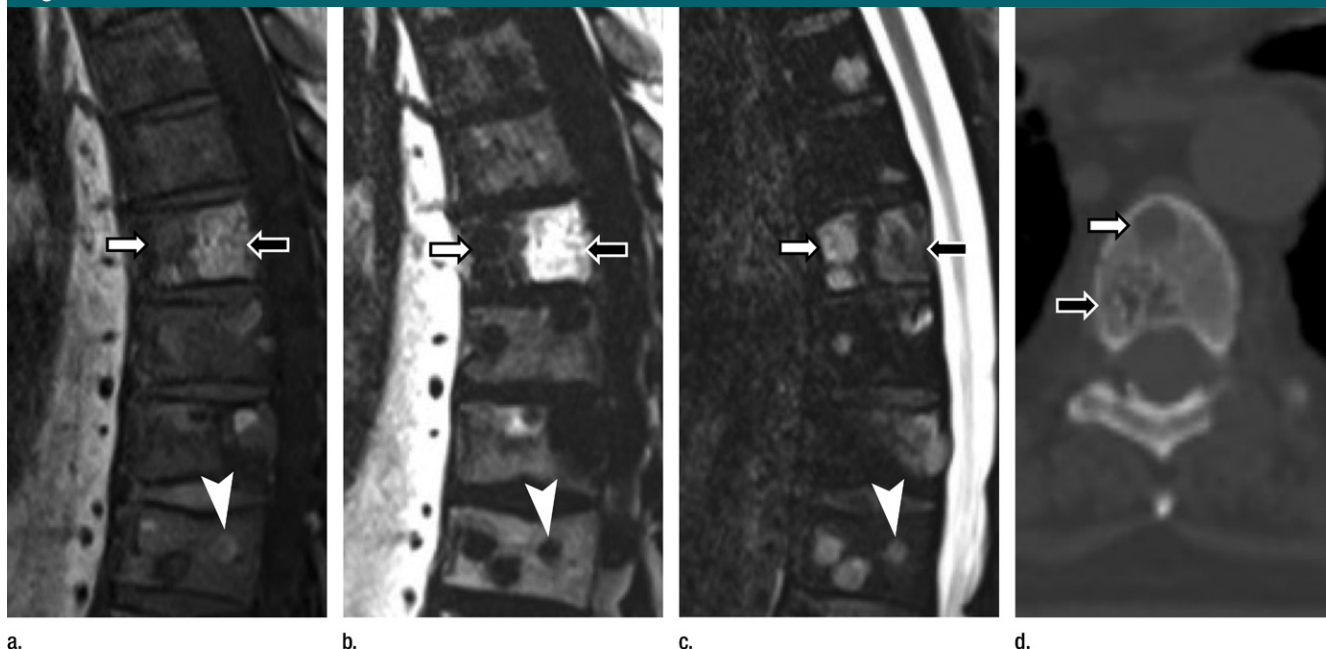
Images in a 66-year-old man with malignant melanoma and lytic bone metastases. Sagittal thoracic spine MR images including (a) T1-weighted, (b) Dixon T2-weighted fat-only, and (c) Dixon T2-weighted water-only sequences. (d) Unenhanced CT image obtained within 3 months of MR imaging, with axial reformat, is also shown. Multiple spinal metastases are visible, all showing high signal intensity on c (white arrow and arrowhead) and with no detectable intralésional signal intensity on b (white arrow and arrowhead), whereas signal intensity varies on a, with some lesions appearing isointense or hyperintense relative to skeletal muscle (arrowhead). Note that on b, hemangioma (black arrow) cannot be differentiated by its signal intensity from metastases on c, whereas it shows fatty content on a and b. (d) CT image shows lytic metastasis (white arrow) and confirms presence of hemangioma (black arrow), with typical thickened trabeculae, which was unchanged over 1 year when compared with previous CT images (not shown).
